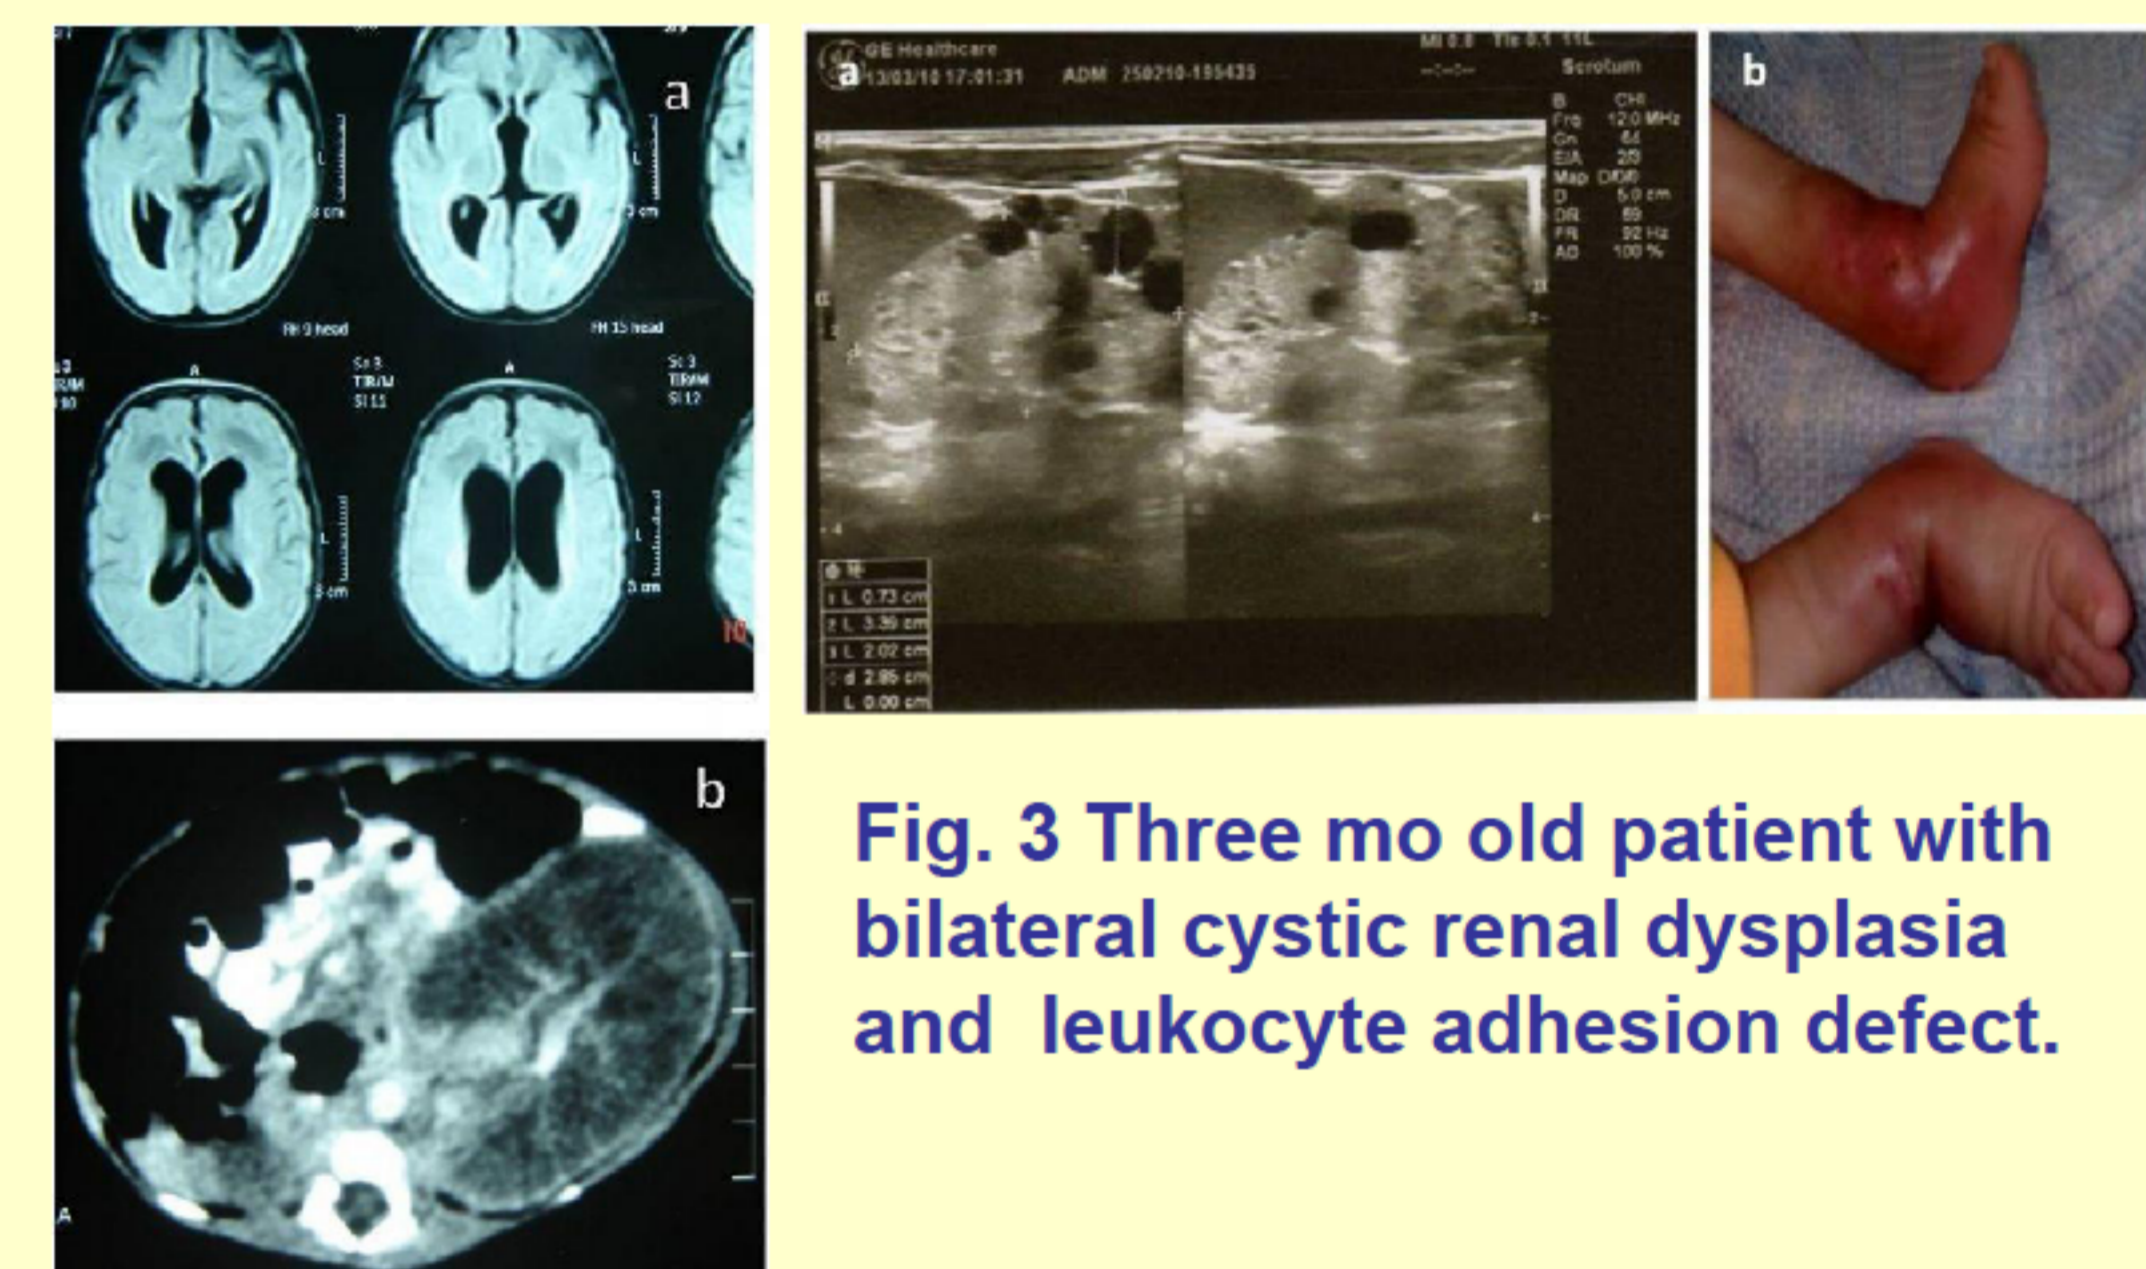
a Brain MRI of a syndromic unclassified case showing ventriculomegaly. b Abdominal CT of the same case showing solitary ARPKD.
